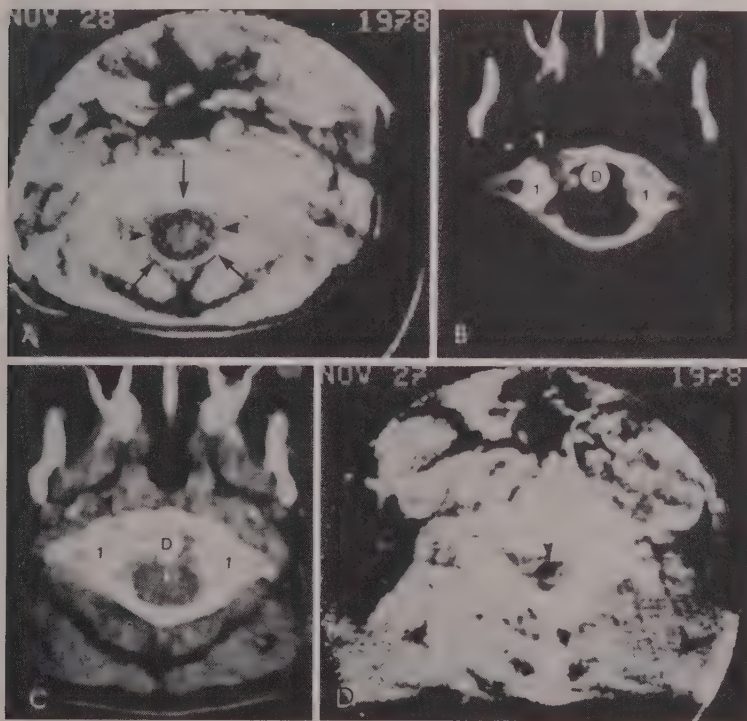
CT of the Spinal Cord.* A, Normal spinal cord at the level of the C2 body. NCT clearly delineates the lucent halo of the subarachnoid space (arrowheads) and the central nearly homogeneous density of the spinal cord. The cervical epidural space (arrows) has a density which is intermediate between the bone and the lucent subarachnoid space. B and C, Fracture of C1 with compression of the subarachnoid space. B, NCT at the level of the C1 ring (1, 1) and dens (D). When adjusted to show bone detail, this NCT reveals a comminuted fracture of the lateral mass of C1 (white arrowhead). C, The identical NCT, adjusted to show soft tissue detail. The fragments and associated soft tissue are displaced posteriorly and narrow the ventral subarachnoid space (white arrowhead), but do not compress the spinal cord itself. D, *Syrinx.* NCT at the level of C4 reveals a very lucent defect (arrowhead) in the central portion of the spinal cord which corresponds to the patient's known syrinx.
